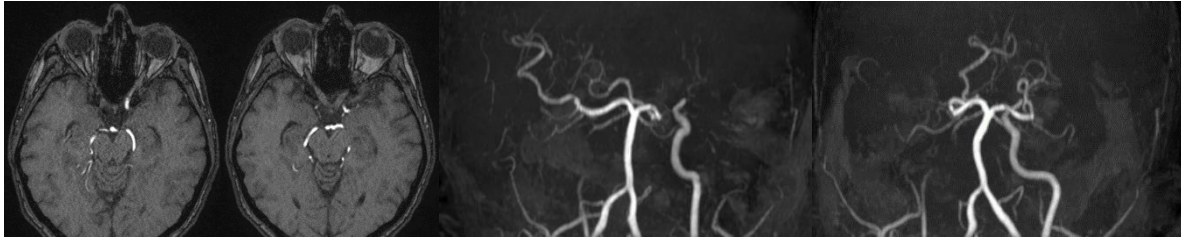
MRI scan of the brain showing no discernible view of the right carotid artery within the intracavernous segment; Markedly inadequate visualization of the anterior circulation.
